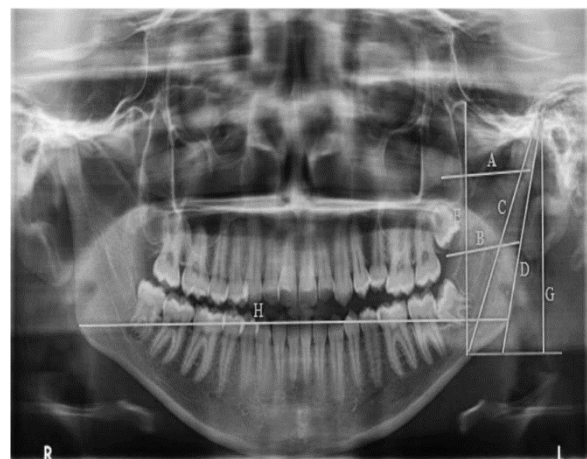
Measurements taken on OPG radiograph
